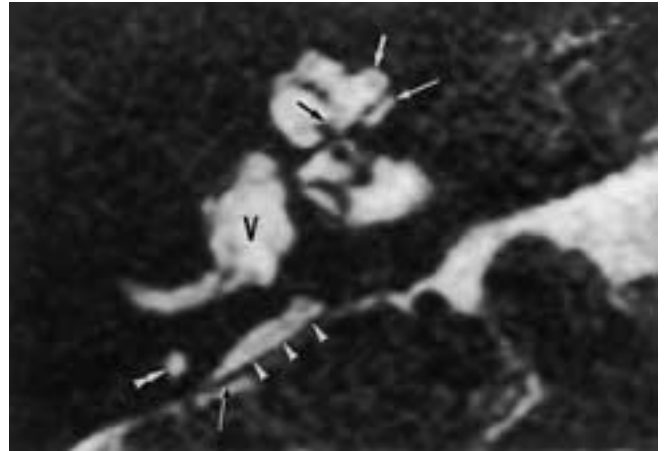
Pendred syndrome: bilateral large endolymphatic sac and duct, with loss of normal fluid in the endolymphatic sac on both sides and in the endolymphatic duct and vestibule on the right side. A, Axial 0.7 mm gradient-echo T2-weighted image through the right inner ear. The endolymphatic duct (*small white arrows*) and sac (*white arrowheads*) are enlarged, and the fluid in these enlarged structures is replaced by low signal intensity soft tissues. Similar signal changes occurred in the ampulla of the lateral semicircular duct (*small black arrows*) and in the posterior part of the vestibule (*black arrowhead*). This lower signal can represent fibrous tissue or loose vascular subepithelial connective tissue and cuboidal to columnar epithelial cells, also called the *rugose* portion. Note that the scala vestibuli/media (*double arrowhead*) is again larger than the scala vestibuli. The asymmetry of the cochlear chambers is, however, less pronounced than in [Figure 21-52](#). Normal fluid inside the posterior semicircular duct (*long white arrow*). B, Axial 0.7 mm gradient-echo T2-weighted image through the left inner ear. The enlarged endolymphatic duct contains normal fluid (*small white arrows*), while the normal fluid in the endolymphatic sac is replaced by soft tissues (*white arrowheads*). Normal fluid can be seen inside the posterior semicircular duct (*long white arrow*). The scala vestibuli/media (*double arrowhead*) is again larger than the scala vestibuli. C, Three-dimensional 3DFT-CISS reconstruction of the inner ear, viewed from above. The fluid-filled cochlea (*C*) and posterior semicircular duct (*double arrowhead*) can be seen. The triangular endolymphatic duct and sac are difficult to recognize because the normal fluid has been replaced by low signal intensity tissue (*white arrowheads*). Low signal intensity can be seen in the ampulla of the lateral semicircular duct (*small white arrows*) and in the posterior part of the vestibule (*long white arrow*).
